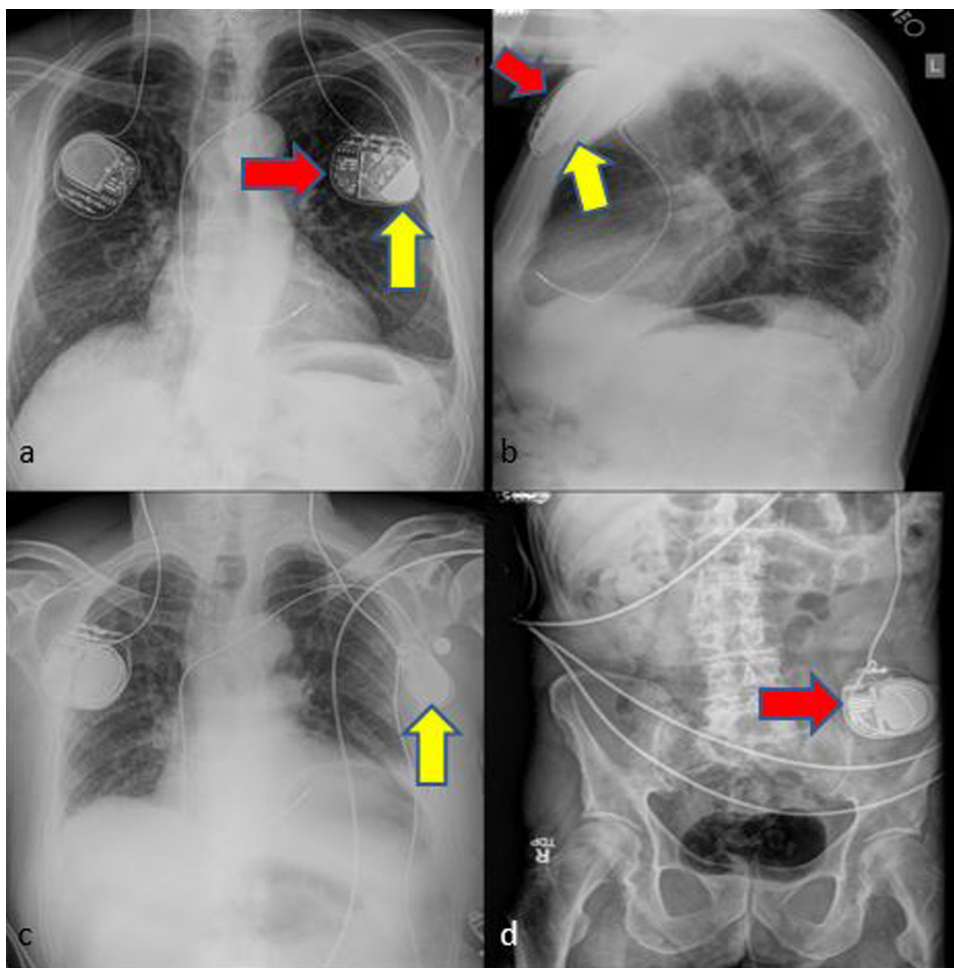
X-ray chest postero-anterior (2a) and lateral view (2b) shows the position of DBS pulse generators and cardiac pacemaker underlying the left chest wall pulse generator. Fig. 2c and d shows the position of left IPG over the left abdominal wall after repositioning. Red arrow indicates the position of DBS IPG and yellow arrow indicates the positioning of cardiac pacemaker.
